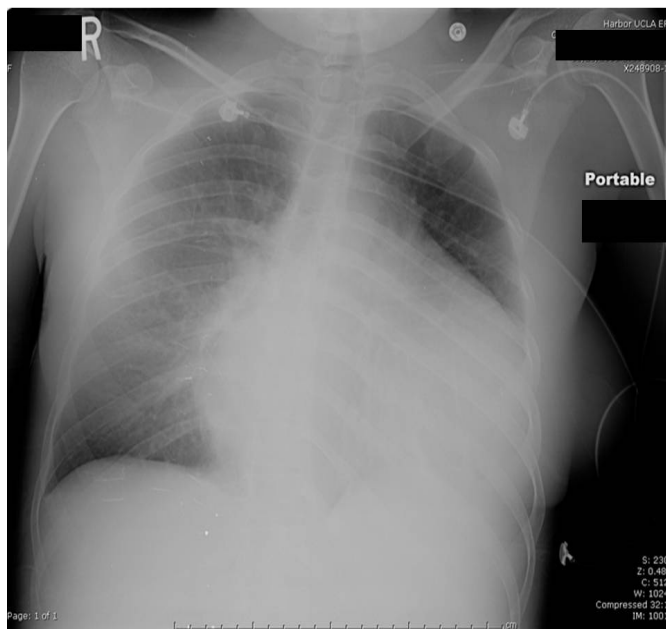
Portable X-ray of patient on admission, showing cardiomegaly and possible left sided pleural effusion.
